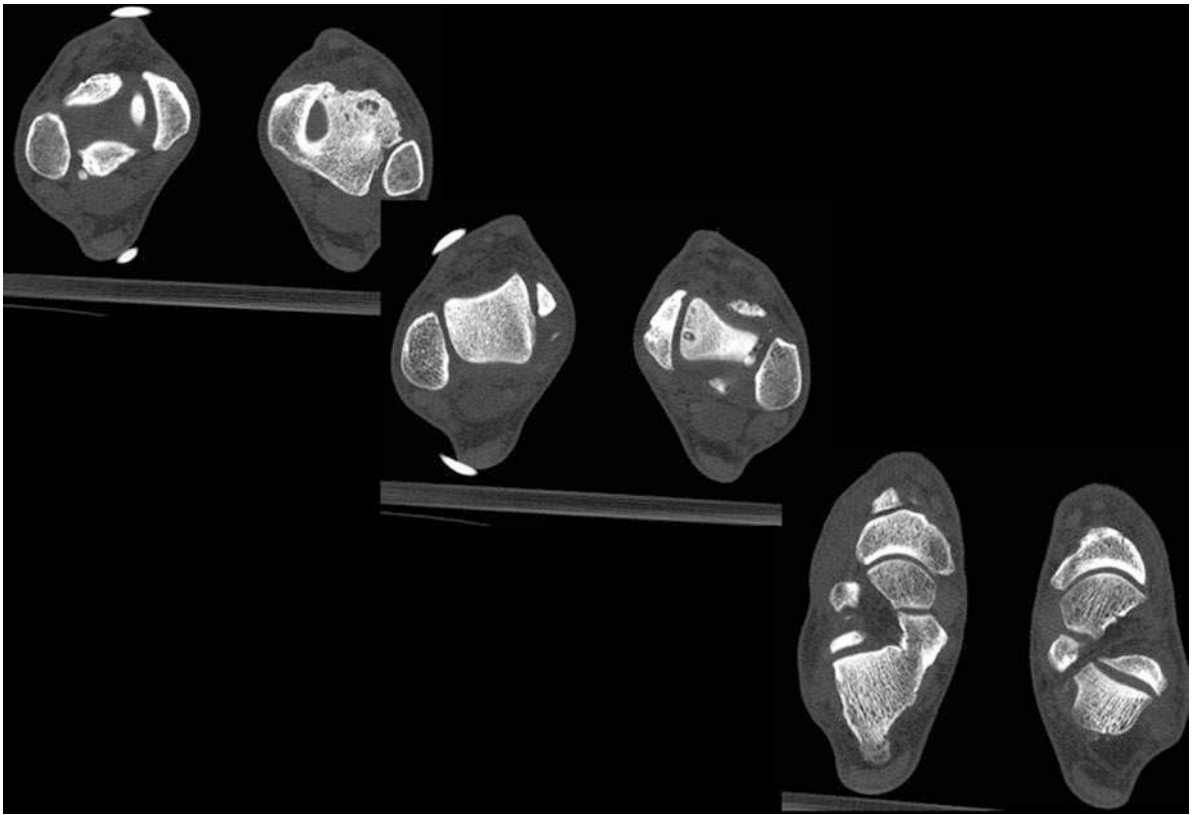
Axial HRCT 0.5 mm of two ankles, mark up of the right one showing OCD in the left talar bone
